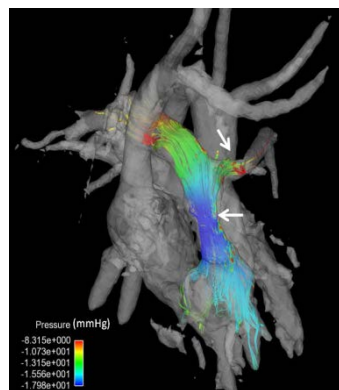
Velocity streamlines from 4D flow MRI in patient with hypoplastic left heart syndrome status post Norwood.
